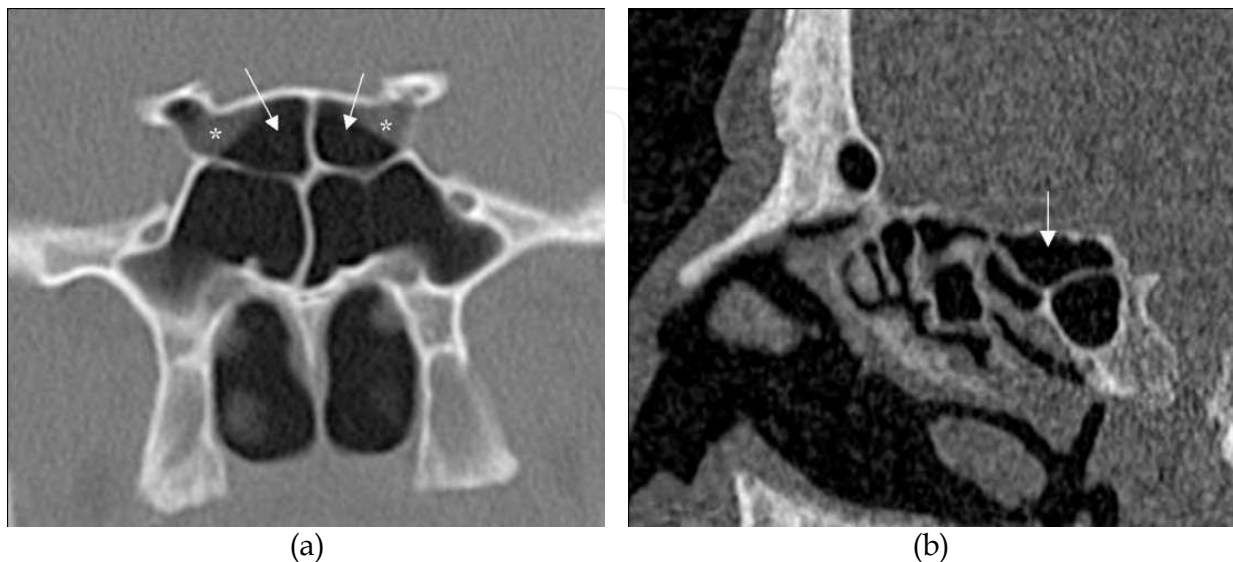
(a) Coronal CT through the sphenoid bone shows four cells, where the superior cells are posterior ethmoid (sphenoethmoid) cells (arrows) that have continued into the sphenoid bone superior to the true sphenoid sinuses. (b) Sagittal CT demonstrates a sphenoethmoid cell (arrow) superior to the true sphenoid cell. Also notice the optic nerves (asterisks) running through the sphenoethmoid (Onodi) cells in fig (a).
